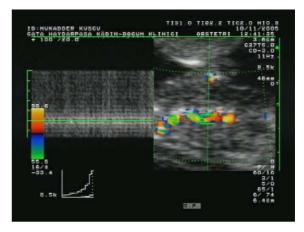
Color doppler analysis stated the highly turbulent flow within the lesion which was confirmed by pulsed wave doppler ultrasonography.
